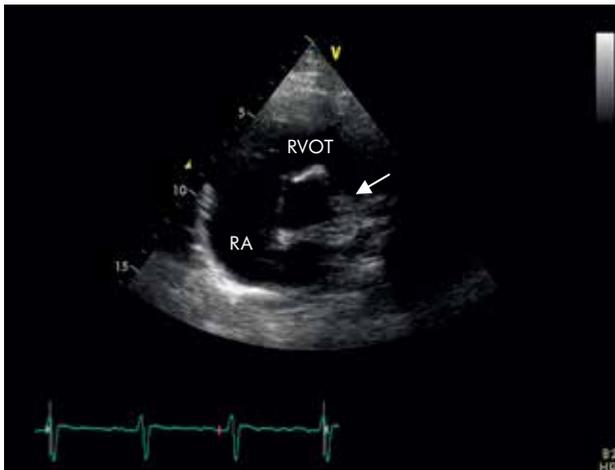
Transthoracic echocardiography. A. Parasternal long-axis view. RV enlargement 34 mm (N: 9–26 mm). RV muscle hypertrophy 10 mm (N: 4–5 mm). B. Parasternal long-axis view. Septomarginal trabecule (arrow). C. Apical four-chamber view. RV enlargement diameter 44 mm (N: 20–35 mm). RA – right atrium, RV – right ventricle, LA – left atrium, LV – left ventricle
